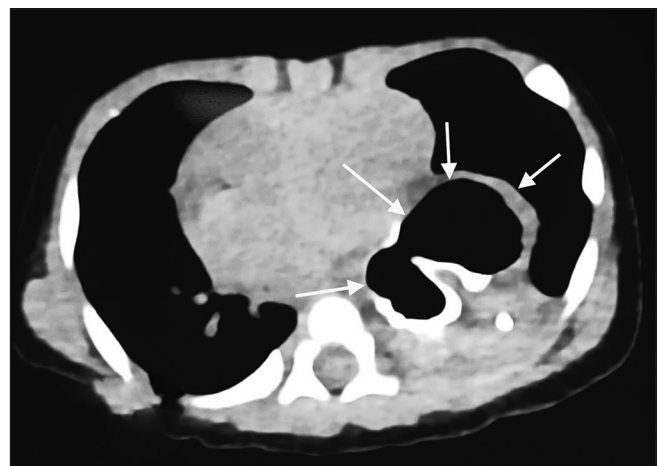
High-resolution computed tomography chest showing the stomach (marked by white arrows) behind the heart shadow.
